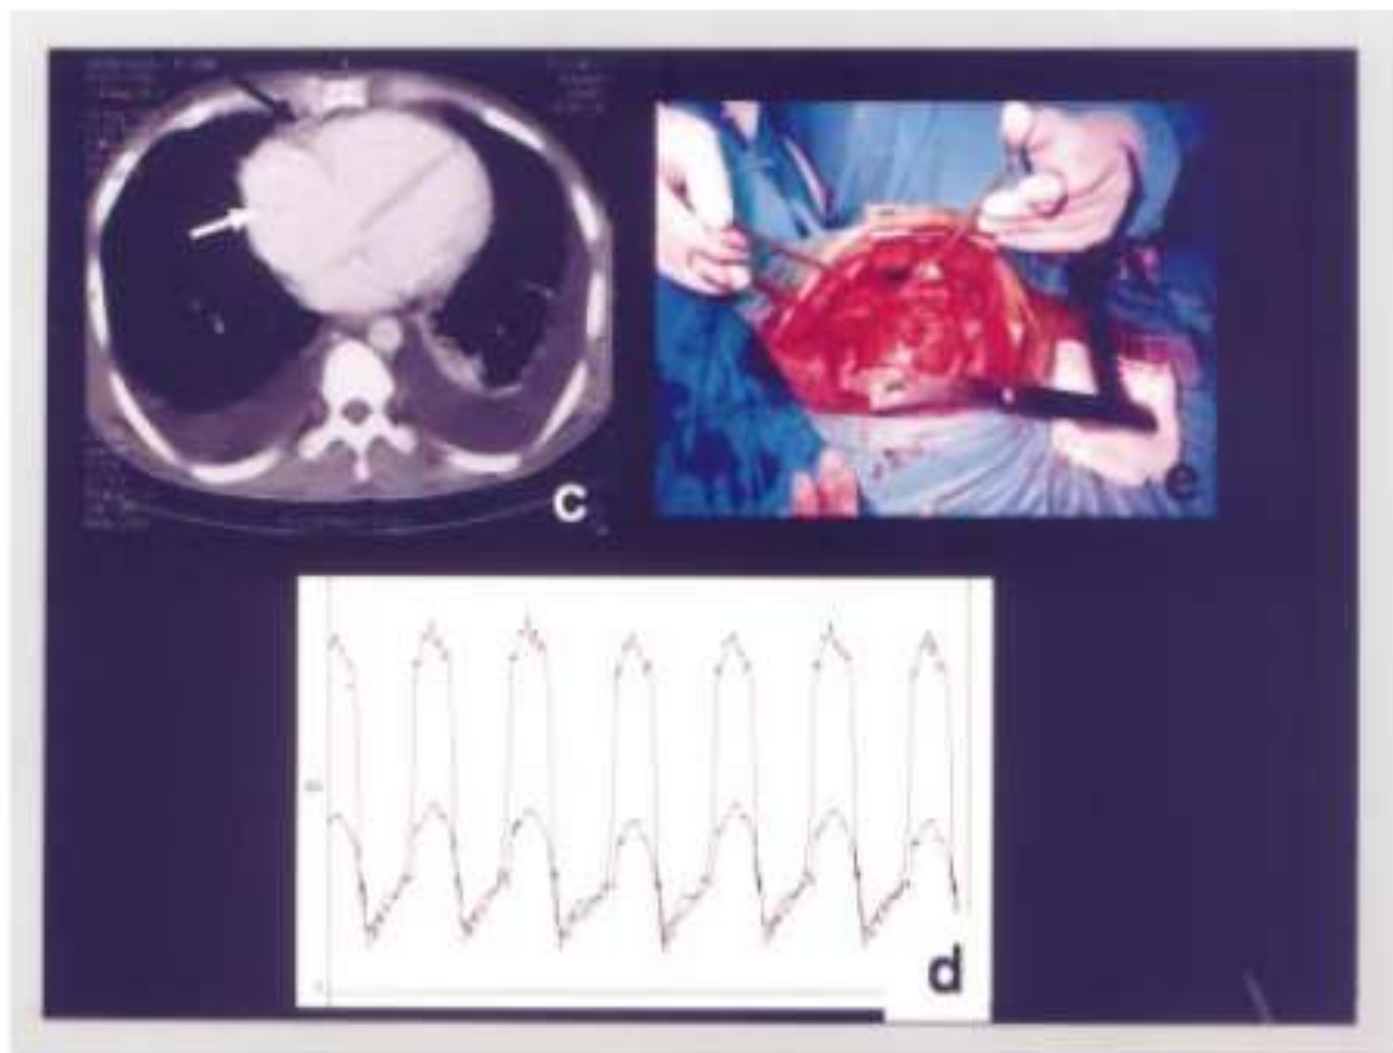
Contrast enhanced CT scan of the chest of a patient with constrictive pericarditis showing thickened pericardium (black arrow) and dilated right atrium (white arrow) (c). Right and left ventricular pressure tracings (paper speed 100 mm/sec and 100 mm Hg gain) of the same patient showing markedly elevated and equal diastolic pressures with mild elevation of right ventricular systolic pressure (45 mm Hg) (d). Operative photograph showing thickened pericardium (e).
